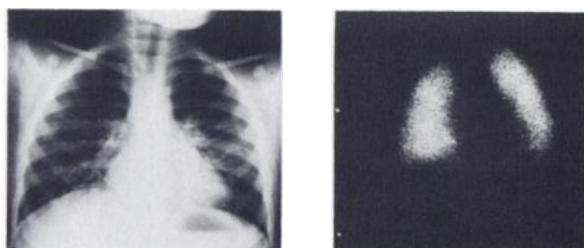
Marked bilateral lesions by radiograph with normal scintigraphy.
